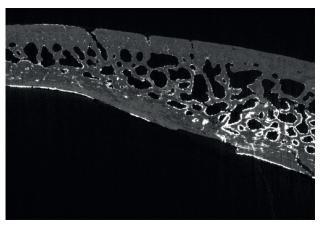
b μ-CT slice (resolution: 12 μm) revealing the widening of the diploë which presents large medullary sinuses, some of which are opened at the surface of external table as porosities. This pattern reflects *hyperostosis spongiosa cranii* (© H. Coqueugniot)
